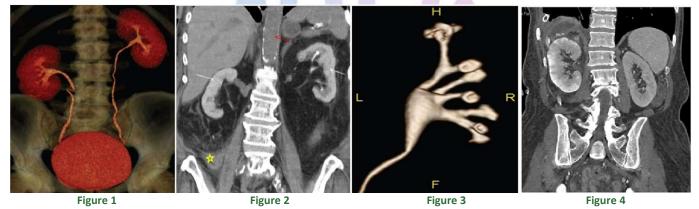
normal three-dimensional volumerendderedcolor-coded excretory phase image of a three-phase CT urogram supplemented with 10mg of intravenous furosemide demonstrates completely distended and opacified collecting systems, ureters, and bladder; Figure 2: Contrast-Induced Nephropathy; Figure 3: Normal MR urogram in adult man. Volume-rendered image of excretory phase, coronal, three-dimensional, fat-suppressed, gradient-echo sequence(repetition time, minimum; echo time, minimum flip angle, 12°; partition thickness, 3mm) at 1.5T with 250mL intravenous normal saline, 5mg intravenous furosemide, and 0.1mmol/kg gadolinium chelate administered 5 minutes prior to acquisition demonstrates detail obtainable with excretory MR urography in the normal intrarenal collection system using diuretic and hydration. F^L fat, H^L head, L^L left, R^L right; Figure 4: Retained contrast in the tubukes right kidney usually means failure but may also be seen in infection.
